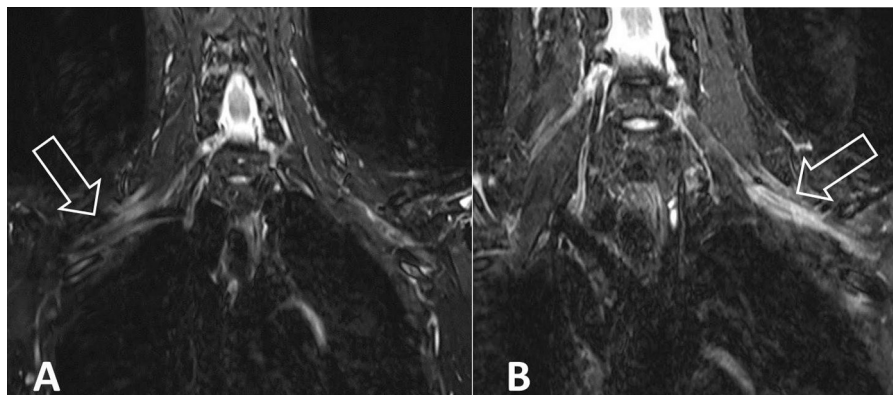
Coronal T2-weighted fat-suppressed images (TR 3700 msec, TI 230 msec, TE 44 msec, Siemens Medical System GMBH, Erlangen, Germany): A, Normal right brachial plexus (arrow). B, Increased signal in fascicles of left brachial plexus (arrow) consistent with inflammatory edema. Fat-suppressed T1-weighted images post intravenous contrast revealed no enhancement (not shown).
